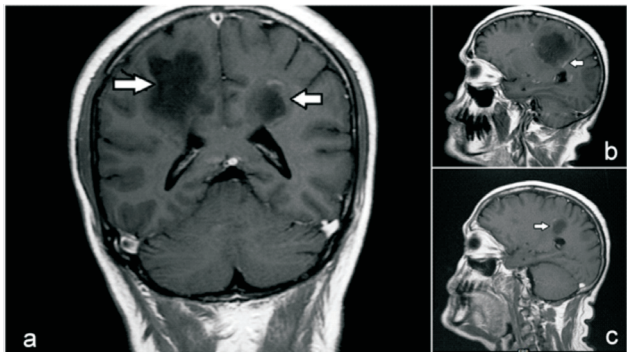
(a, b & c): Coronal (a) & sagittal (b & c) post gadolinium T1 weighted FLAIR images showing concentric ring enhancement (Arrows).
